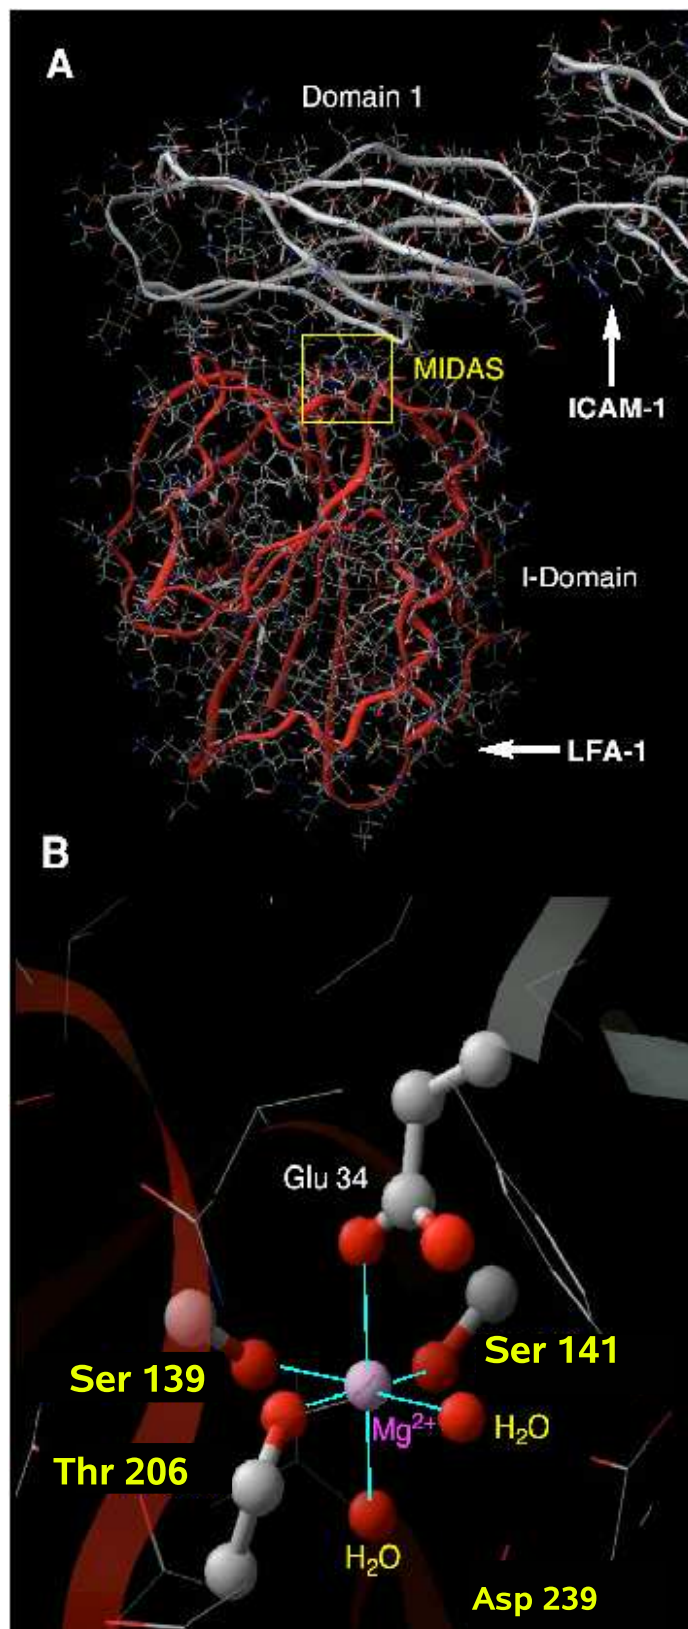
A) Ribbon representation of the X-ray structure of the medium affinity conformation of the I-domain in LFA-1 (red), interacting with ICAM-1 (white) (PDB ID:1MQ8 [60]). B) Highlighted the MIDAS motif (*open* state) in a ball and stick representation, where GLU-34 of ICAM-1 completes the coordination sphere of the metal
